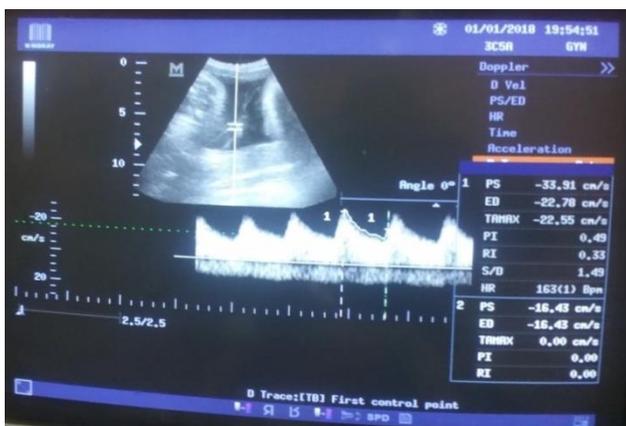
Shows color Doppler umbilical artery waveform at 38 weeks
